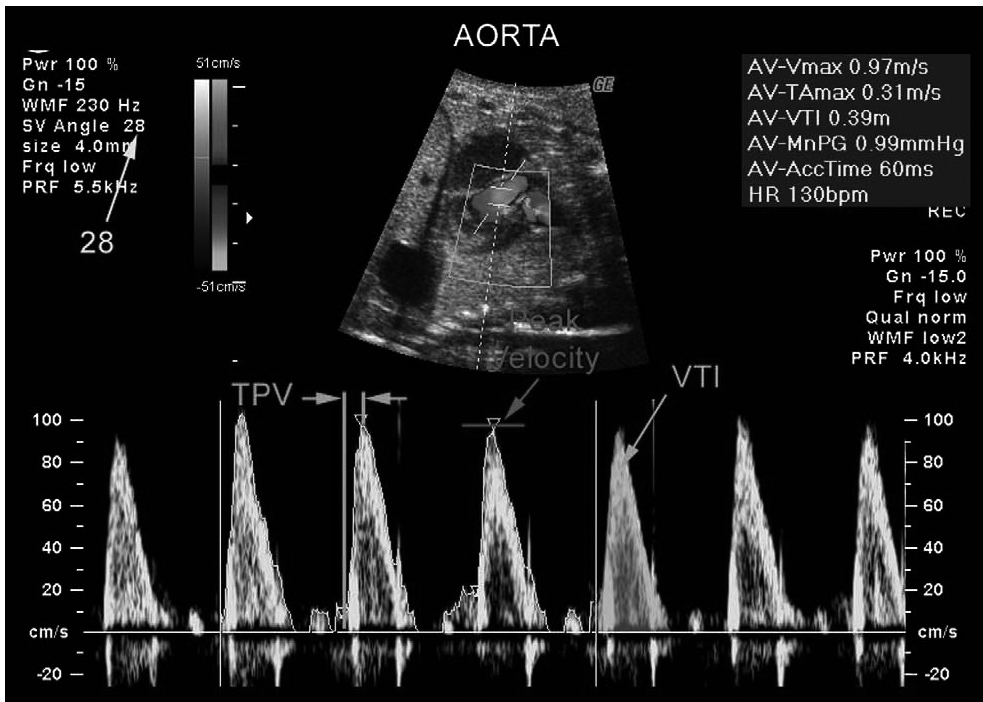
Measurement of aortic blood flow with correct cursor placement for pulsed-wave Doppler interrogation. A single peaked Doppler waveform is shown below. Velocity time integral (VTI) is marked in blue, peak velocity measurement is marked in purple and measurement of the time to peak velocity (TPV) is marked in green. Adapted from *Seminars in Fetal & Neonatal Medicine* (2005) 10, 515-541.
